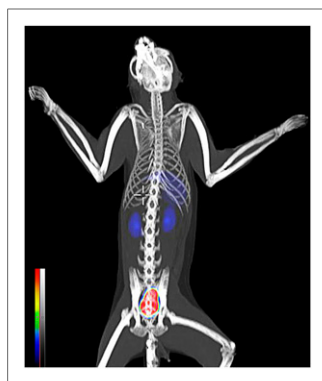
Representative ^{68}Ga -NOTA-UBI PET/CT biodistribution in NHPs 60 min after tracer administration (189 MBq).
